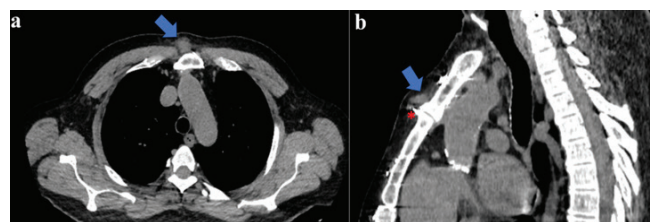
Axial (a) and sagittal (b) scans of chest computed tomography show a 17 mm, well-circumscribed soft tissue mass in the presternal region (arrow) and a malpositioned sternal wire (asterisk).
